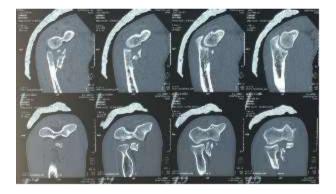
CT scan of the elbow
